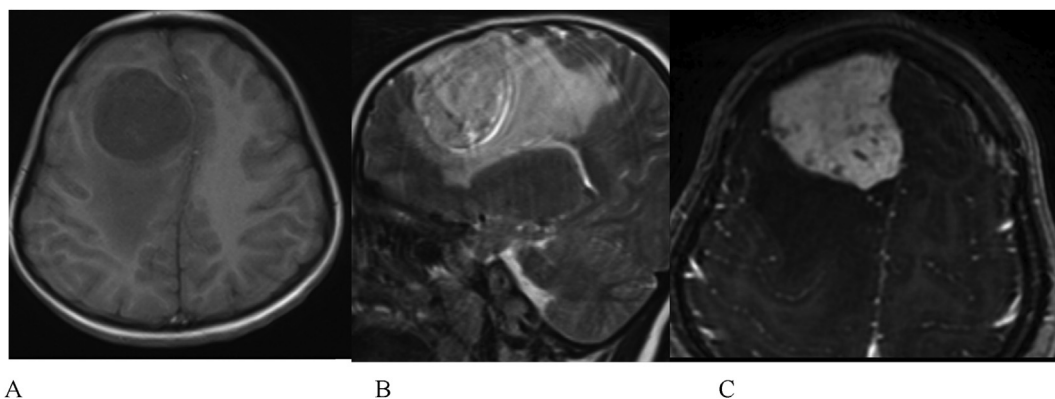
A 7-year-old girl complaint of headache for 1 year. Brain MRI showed a solitary, well-demarcated mass in the right frontal lobe. The lesion was hypointense on TIWI, and heterogenous high signal on T2WI. After injecting contrast agent, the tumor showed strong homogenous contrast enhancement with a close connection with dural base.
